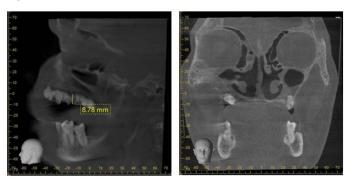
CBCT Lateral And Coronal View
